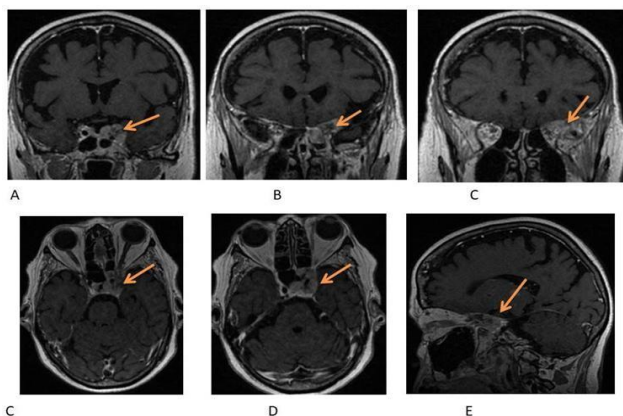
MRI scans showing tumor location and radiological anatomy.
